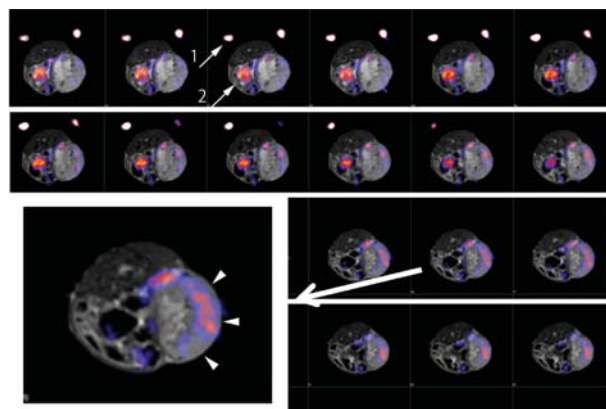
In vivo* fusion imaging of intratumoral distribution of ^{125}I -POS and MR images. A representative image is enlarged. Arrows 1: markers, arrows 2: urinary bladder, and arrowheads: the tumor.
